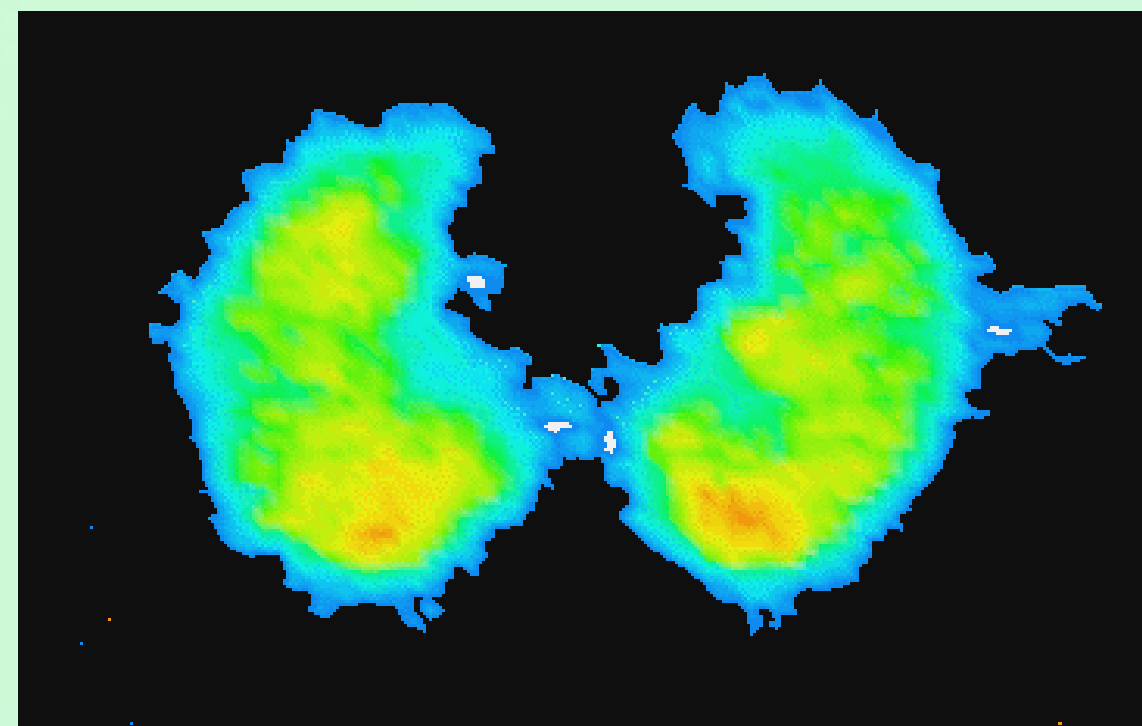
An example of an aligned single photon emission computer tomographic (SPECT) image corresponding to a transverse MR slice.
